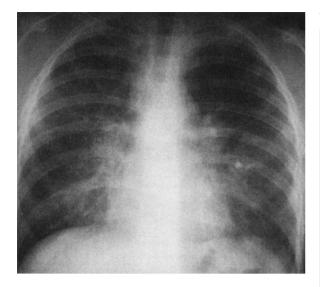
Chest radiograph of an 11-year-old boy with EAA (for details see text). After a short course of oral corticosteroids a complete resolution is seen with fading pulmonary parenchymal shadows
